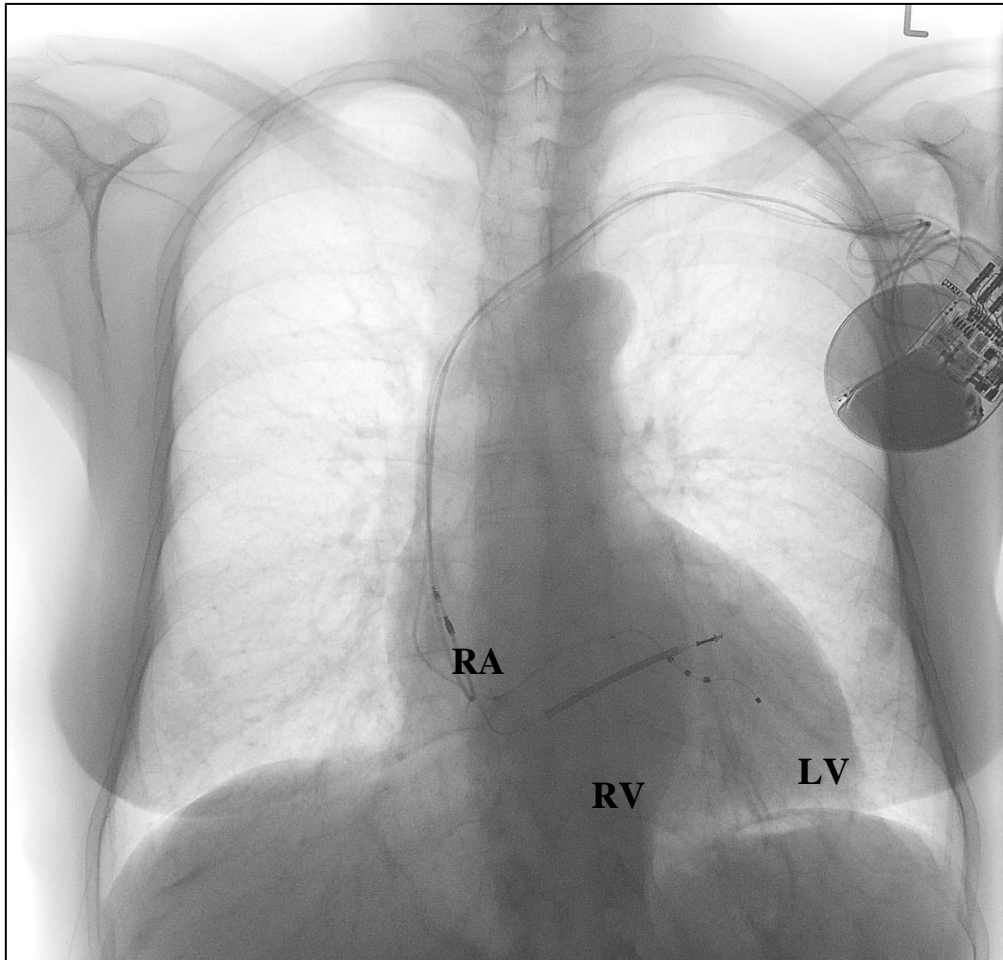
Antero-posterior X-ray of a patient with a CRT-D system. RA: right atrial, bipolar lead; RV: right ventricular, bipolar, single-coil ICD lead; LV: left ventricular, quadripolar lead in a lateral side branch of the coronary sinus
